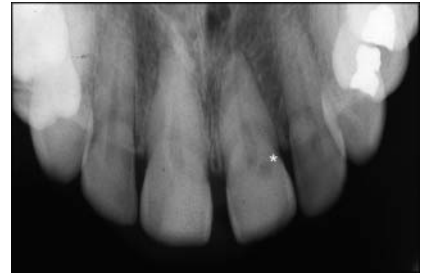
The occlusal radiograph denotes a small invasive resorptive lesion (*) near the cervical area with a shallow penetration into the dentin.
